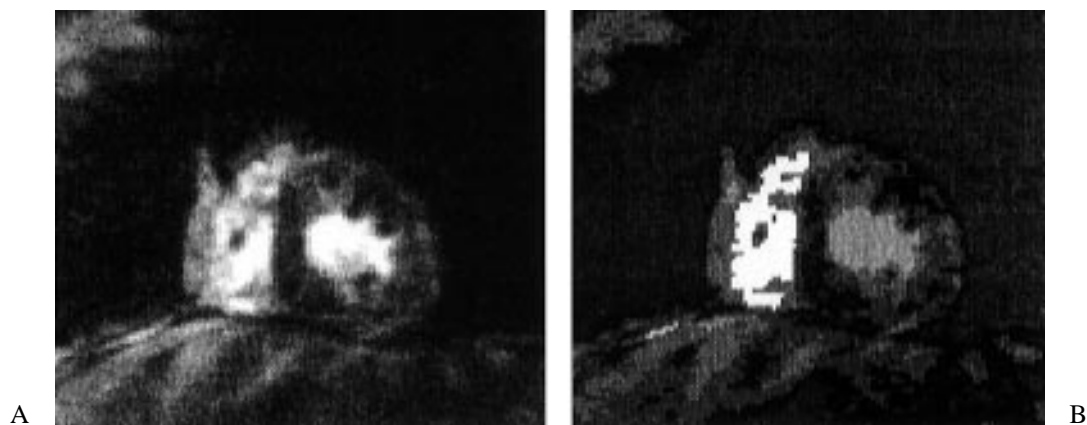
MR image of the middle of the heart of patient 2 at end-diastole. Smoothing of (A) with a median filter (B).
